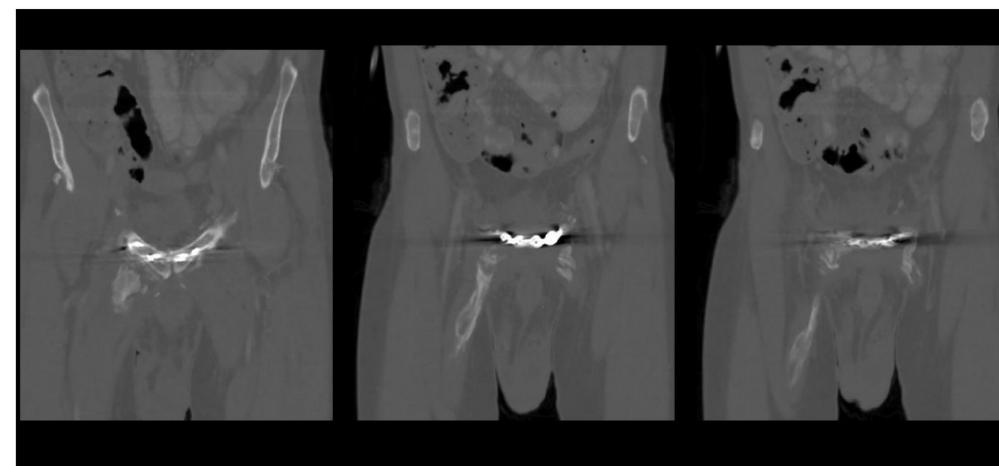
CT Coronals 11/2018
